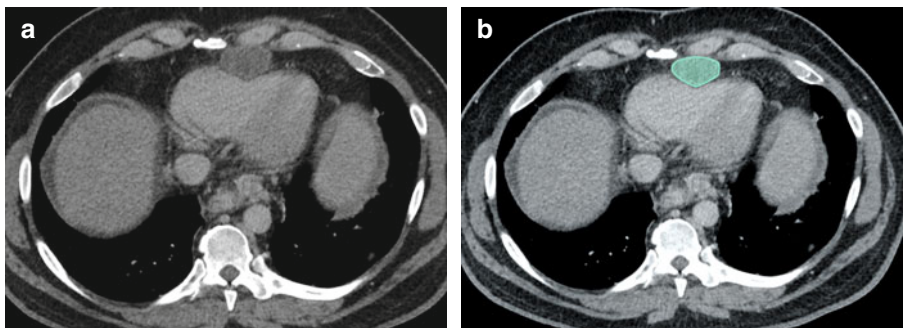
(a, b) Axial contrast-enhanced CT scan of the thorax shows enlarged pericardial lymph node in a case of hepatocellular carcinoma (*green*)
